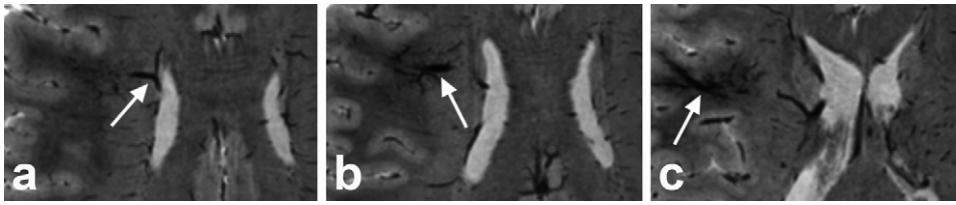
a–c, Axial 1st echo minMIPs (over 10 mm thick volumes) of T_2^* -weighted 7T MR images of a 22-year-old healthy female volunteer showing a developmental venous anomaly, a benign condition not requiring any treatment if asymptomatic [58]. Due to the increased susceptibility effect of venous deoxygenated blood at high magnetic field, the venous structure can be assessed even at a TE = 2.5 ms, as well as its various branches (arrow in a–c). Imaging parameters as previously published [33].
